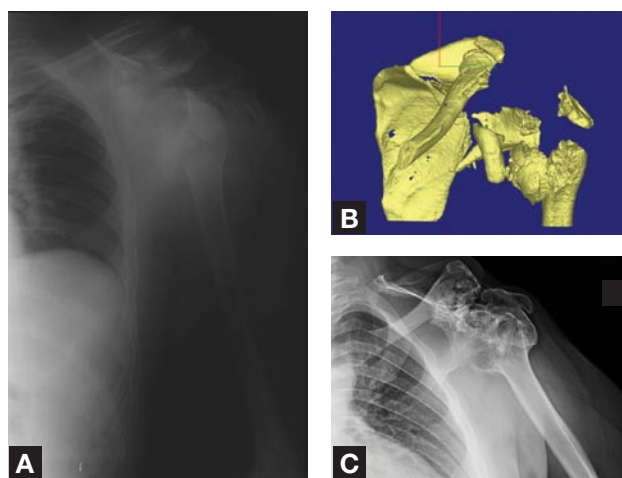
(A) Injury x-ray and (B) 3-dimensional anteroposterior reconstruction image of comminuted proximal humerus, glenoid, acromion, and coracoid fractures with articular destruction and significant bone loss secondary to blast injury. (C) X-ray of same patient 5 months after surgery shows glenohumeral arthrodesis consolidation.
